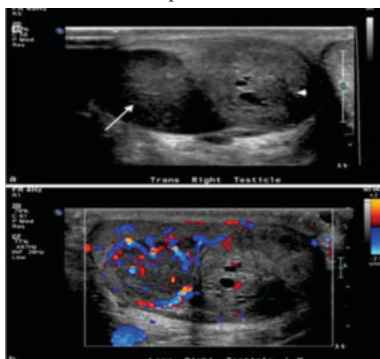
(a) Axial Section Of Scrotum Showing Mass Lesion (Gray Scale USG), (b) Axial Section Of Scrotum Showing Internal Vascularity Of Mass Lesion (Colour Doppler Study).
